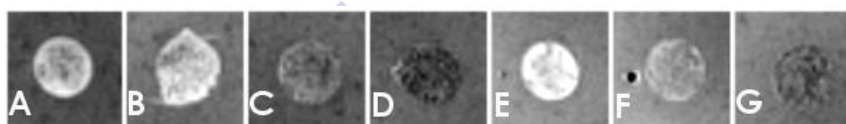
T2-weighted images of MSCs. (A) Control; (B) 200 $\mu g/mL$ of D-MNPs and No PLL, (C) 200 $\mu g/mL$ of D-MNPs and 0.75 $\mu g/mL$ of PLL, (D) 200 $\mu g/mL$ of D-MNPs and 1.5 $\mu g/mL$ of PLL, (E) 100 $\mu g/mL$ of D-MNPs and No PLL, (F) 100 $\mu g/mL$ of D-MNPs and 0.75 $\mu g/mL$ of PLL, (G) 100 $\mu g/mL$ of D-MNPs and 1.5 $\mu g/mL$ of PLL.
